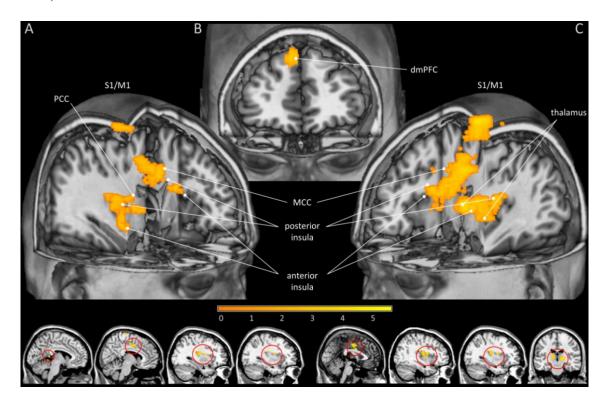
Differences in neural responses to conditioned stimuli during early acquisition. Differential CS-induced neural responses in a priori defined ROI in cingulate, insular, sensory-motor, thalamic and prefrontal regions between (A) pain-predictive CS^+ [$CS^+_{VIS} < CS^+_{SOM}$], between (B) somatic [$CS^+_{SOM} < CS^-$], and (C) visceral pain-predictive CS^+ compared to the CS^- [$CS^+_{VIS} < CS^-$] [in all contrasts: $p_{FWE} < .05$]. For more details on BOLD data analyses, see Tab.4 and result section (4.2.5.1.) Activations were superimposed on a structural T1-weighted MRI used for spatial normalization and thresholded at p < .001 uncorrected for visualization purposes. Color bars indicate t-scores. Abbreviations: CS, conditioned stimuli; dmPFC, dorsomedial prefrontal cortex; M1, primary motor cortex; MCC, midcingulate cortex; PCC, posterior cingulate cortex; S1, primary somatosensory cortex.
